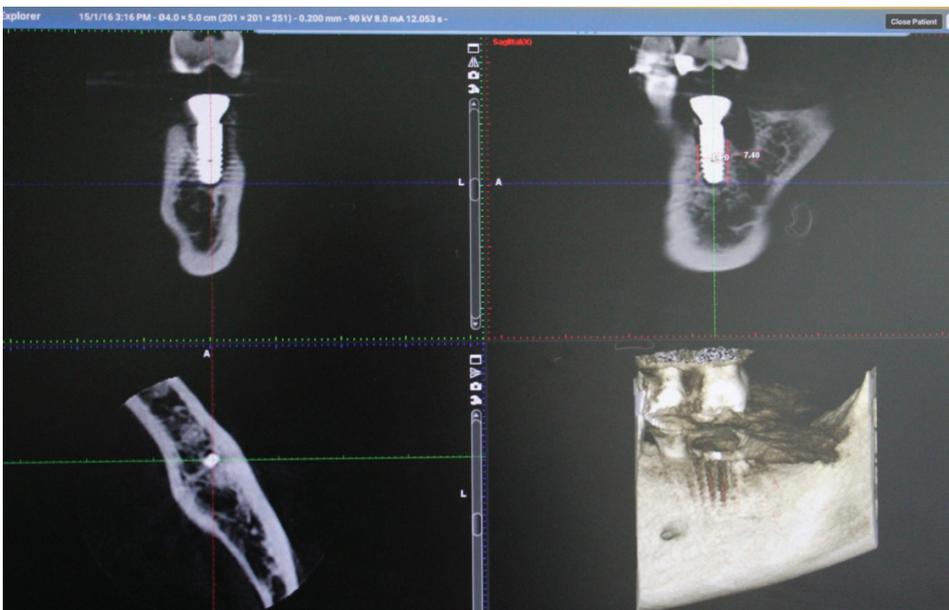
CBCT 6 months after implant placement.
